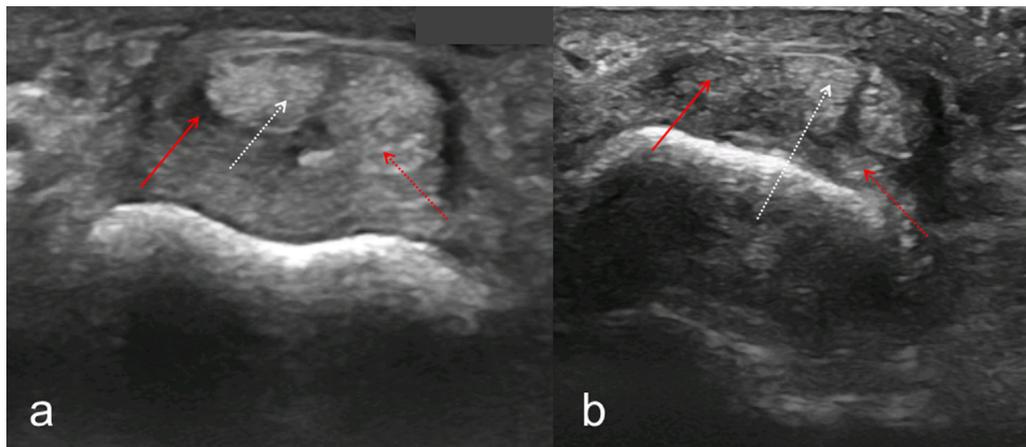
Ultrasound cross-sectional view at the PIP joint volar plate (a) and between the A3 and A2 pulleys (b). Red dotted arrow depicts the remaining ulnar FDS slip, red continuous arrow shows the tendon missing (a) and crimped up (b), white dotted arrow indicates the FDP tendon.
